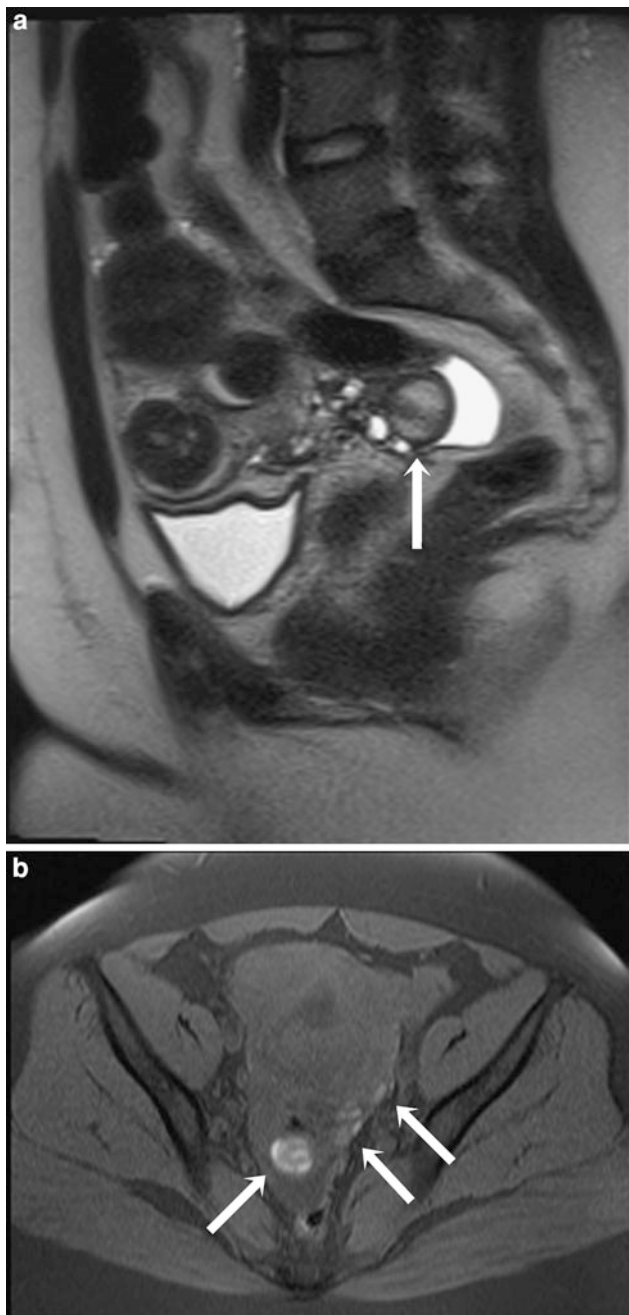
Fibroids and endometriosis. A 30-year-old with an interest in future pregnancy with heavy bleeding and severe perimenstrual pain. a Sagittal T2-weighted MR image demonstrating fibroids and a mixed signal complex cyst posteriorly, compatible with an endometrioma (*white arrows*). b Axial T1-weighted image with high signal small cyst and other foci of high signal, corresponding to the endometrioma and additional endometriosis implants. In this patient, menstrual bleeding was only mildly increased and the primary complaint was severe menstrual pain. Patient was referred for management of endometriosis, with treatment for fibroids deferred until they are more symptomatic
